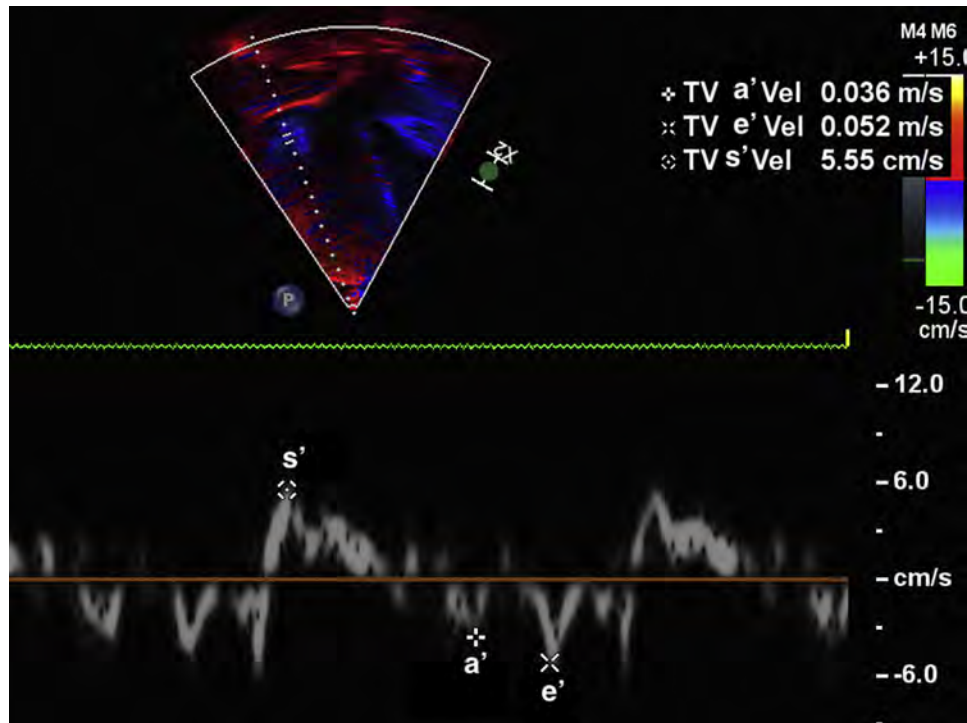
Doppler tissue image of the RV free wall in a patient after the AtrSO demonstrates significantly diminished s' velocity (5.5 cm/sec) and e' -to- a' reversal suggestive of both systolic and diastolic dysfunction.
